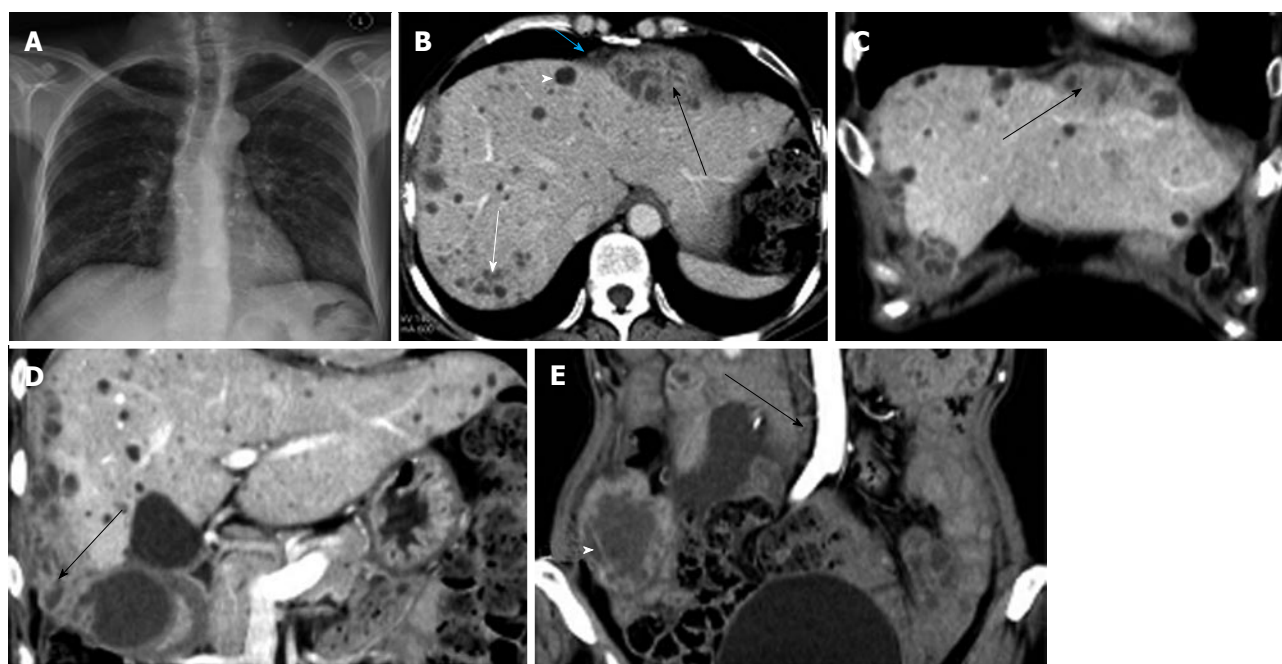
Three tuberculous abscesses located in the abdominal cavity. A: Chest X-ray film showed active pulmonary tuberculosis; B, C: Axial and coronal CT images showed a multisepated, peripherally enhanced, hypodense mass located in the subphrenic space measuring 3.0 cm × 3.5 cm × 7.2 cm (black arrow). A liver tuberculous lesion (white arrow) and liver cyst (arrowhead) were also detected. Nodular thickening of the diaphragmatic peritoneum showed homogeneous enhancement (blue arrow); D: Coronal CT image showed a multisepated, peripherally enhanced, hypodense mass with irregular shape located in the perihepatic space measuring approximately 5.0 cm × 8.9 cm × 12.2 cm (arrow); E: Coronal CT image showed a multisepated, peripherally enhanced, hypodense mass located in the lower abdominal cavity measuring approximately 4.5 cm × 5.8 cm × 7.0 cm (arrow head). Enlarged lymph nodes with rim enhancement located in the para-aortic region were detected (arrow). CT: Computed tomography.
